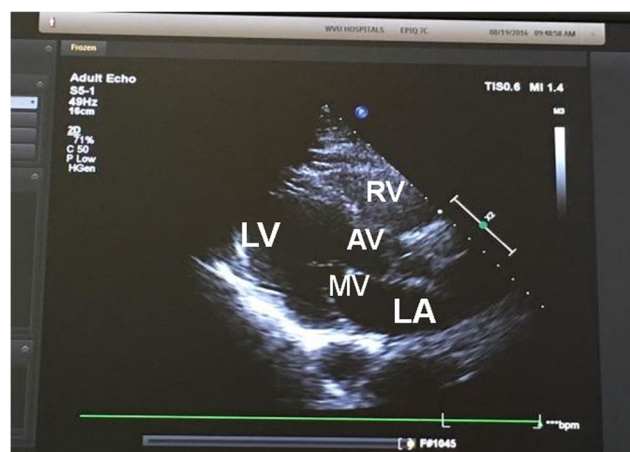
Parasternal long-axis TTE view. *legend* This view can evaluate biventricular contractility and valvular morphology. RV right ventricle, AV aortic valve, MV mitral valve, LA left atrial, LV left ventricle
